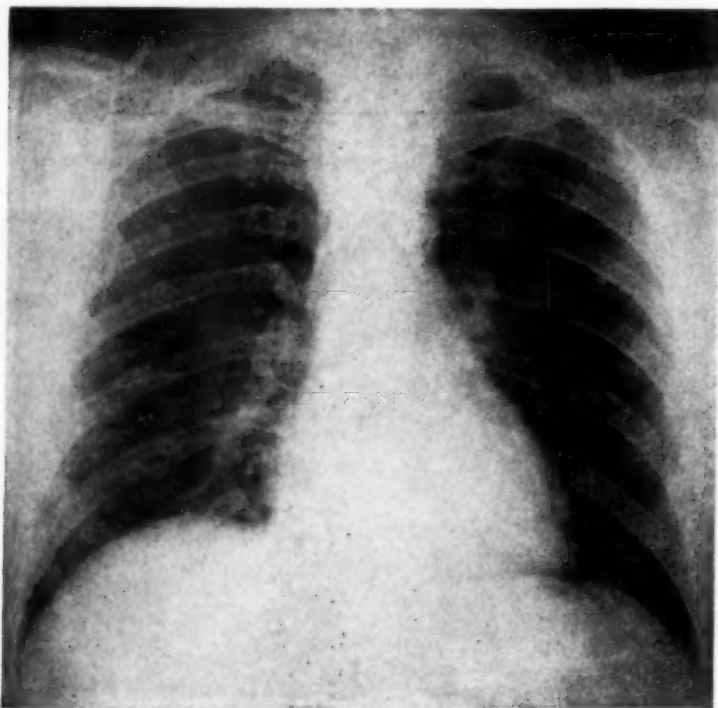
Roentgenogram of chest on twenty-first day of disease, showing return to normal.
